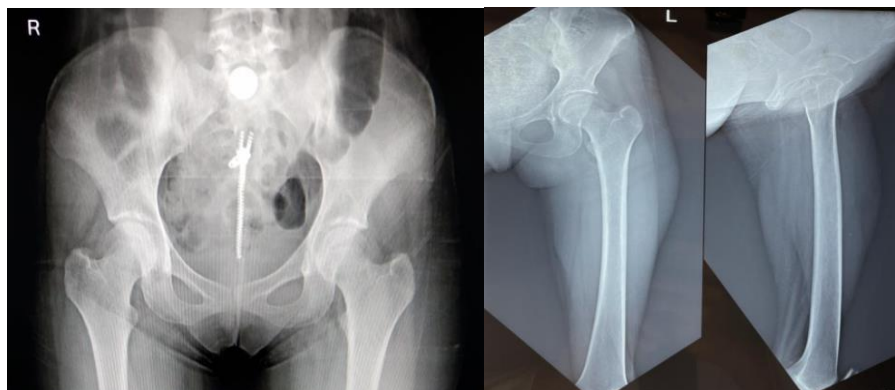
Radiographs showing both SI joints in AP view and Left SI joint in AP and lateral view respectively.
